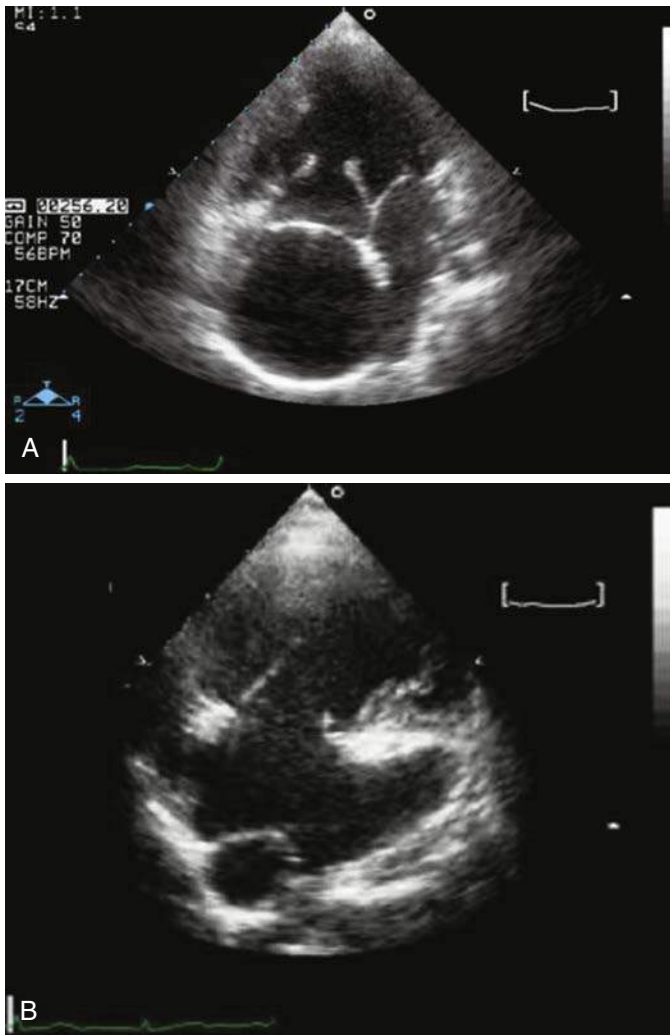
Transthoracic echocardiography two-dimensional apical four-chamber view from a patient with a univentricular heart. A, After Fontan procedure and (B) after total cavopulmonary connection procedure.
